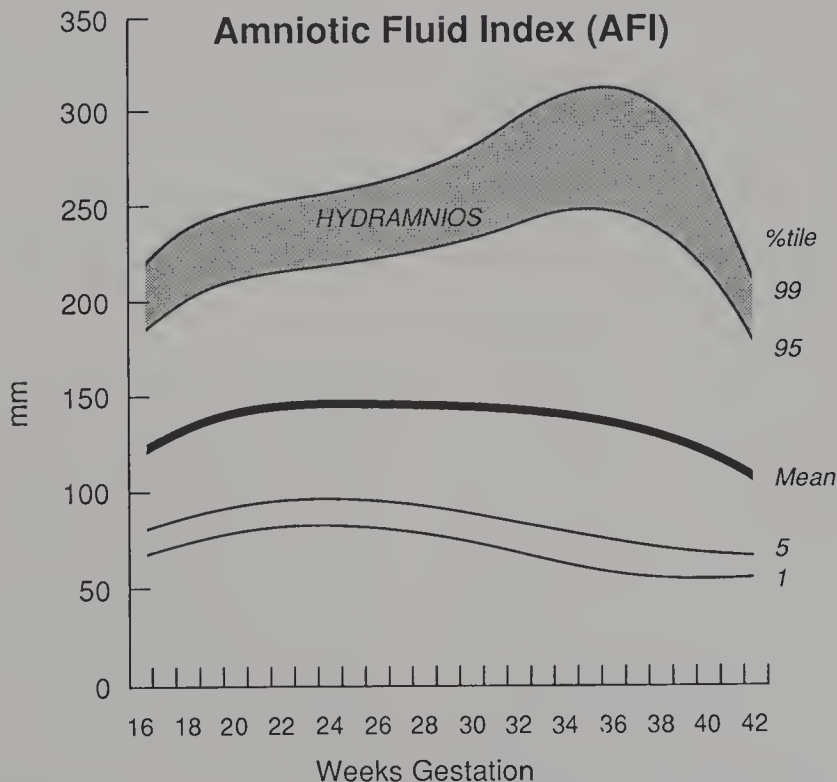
The amniotic fluid index represents the sum (mm) of four pockets from each quadrant of the uterus determined by measurements during ultrasonography. An index that exceeds the 95th percentile indicates hydramnios. The mean (50th percentile) is indicated by the *heavy black line*. Values characteristic of hydramnios are shown in the *dotted area*.
